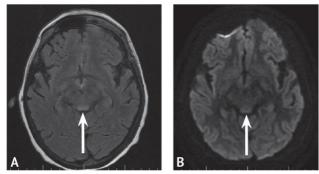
Magnetic resonance imaging of the brain of patient M. A — T2 FLAIR-images, axial section, the arrow indicates the high signal area in the region of the quadrigeminal plate; B — DWI-images, axial sections, the arrow indicates the area of weakly hyperintensive signal from the quadrigeminal plate, specific for Wernicke encephalopathy
